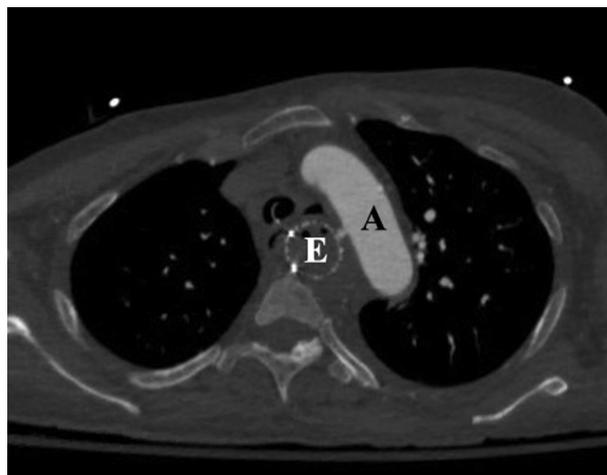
CT angiography scan of the chest (axial view). Fistula between the esophageal stent and aortic arch. A, Aortic arch; E, esophageal stent.
